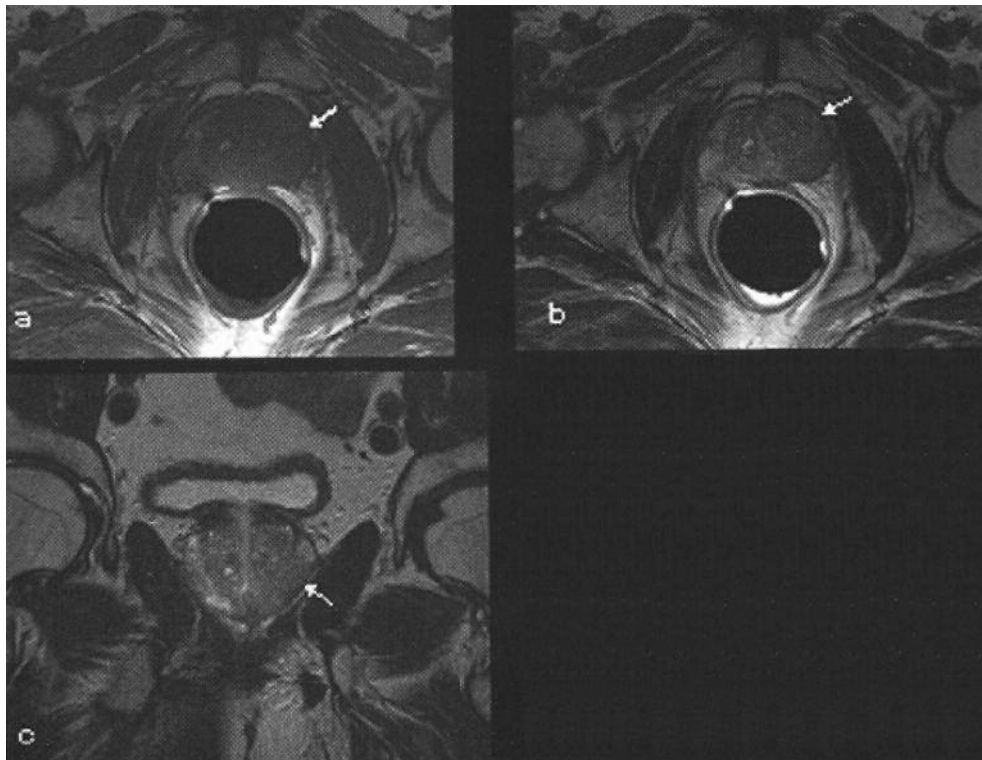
MR images representing lidocaine injection areas.
